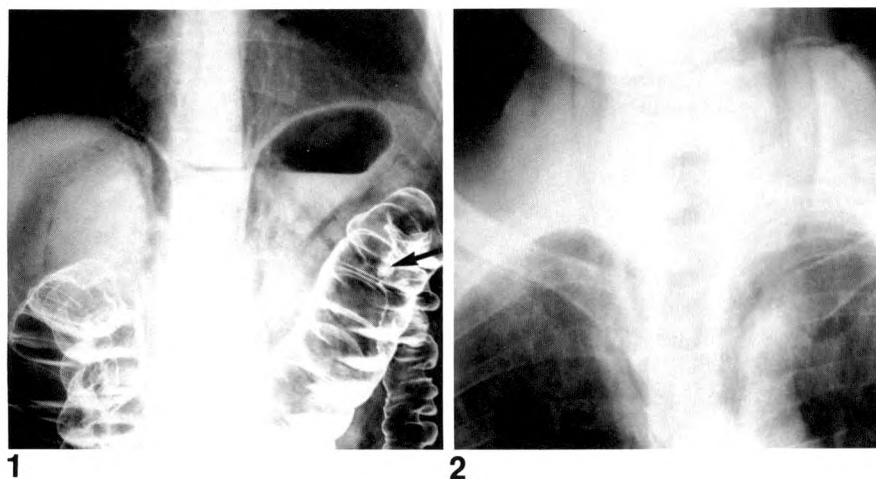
Upright radiograph made during air-contrast barium enema shows pneumoperitoneum and gas in retroperitoneum tracking into mediastinum. Arrow indicates site of extravasation of contrast material.
